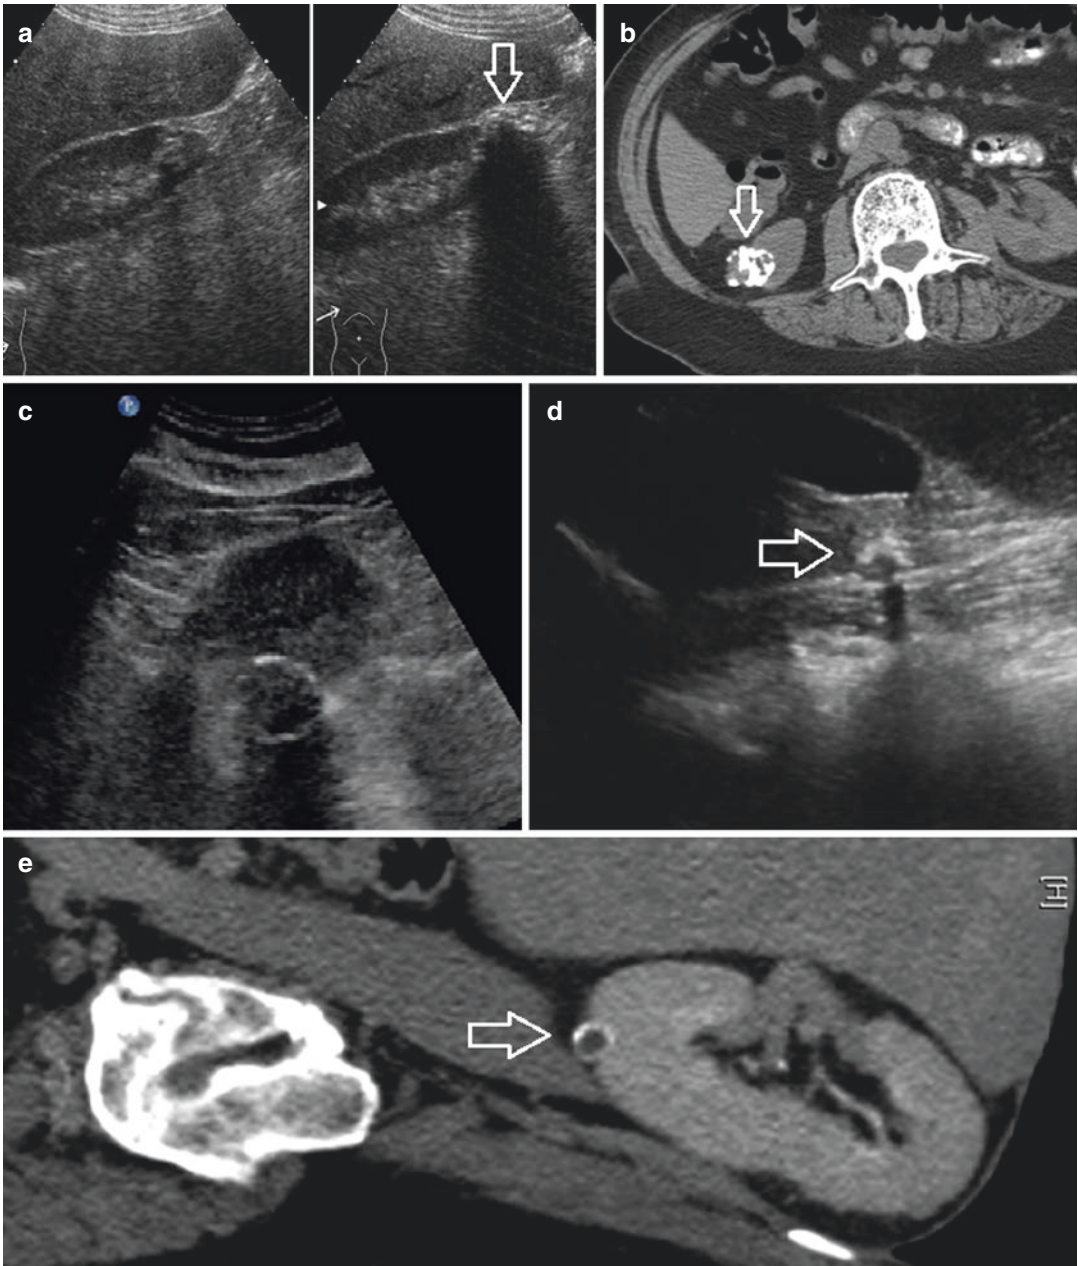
(a) A cystic lesion with parietal and inner calcifications. This determines the formation of a wide posterior acoustic shadowing. (b) CT axial view. (c) Echoic annular image with posterior positive through transmission due to
